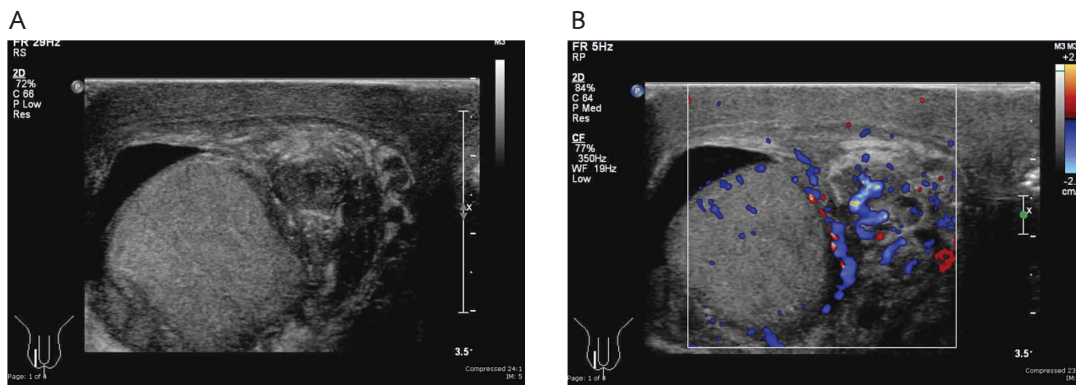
Gray-scale (A) and color Doppler (B) sonography of patient with right epididymo-orchitis show enlarged and heterogeneous echogenicity with increased flow of the epididymis.
